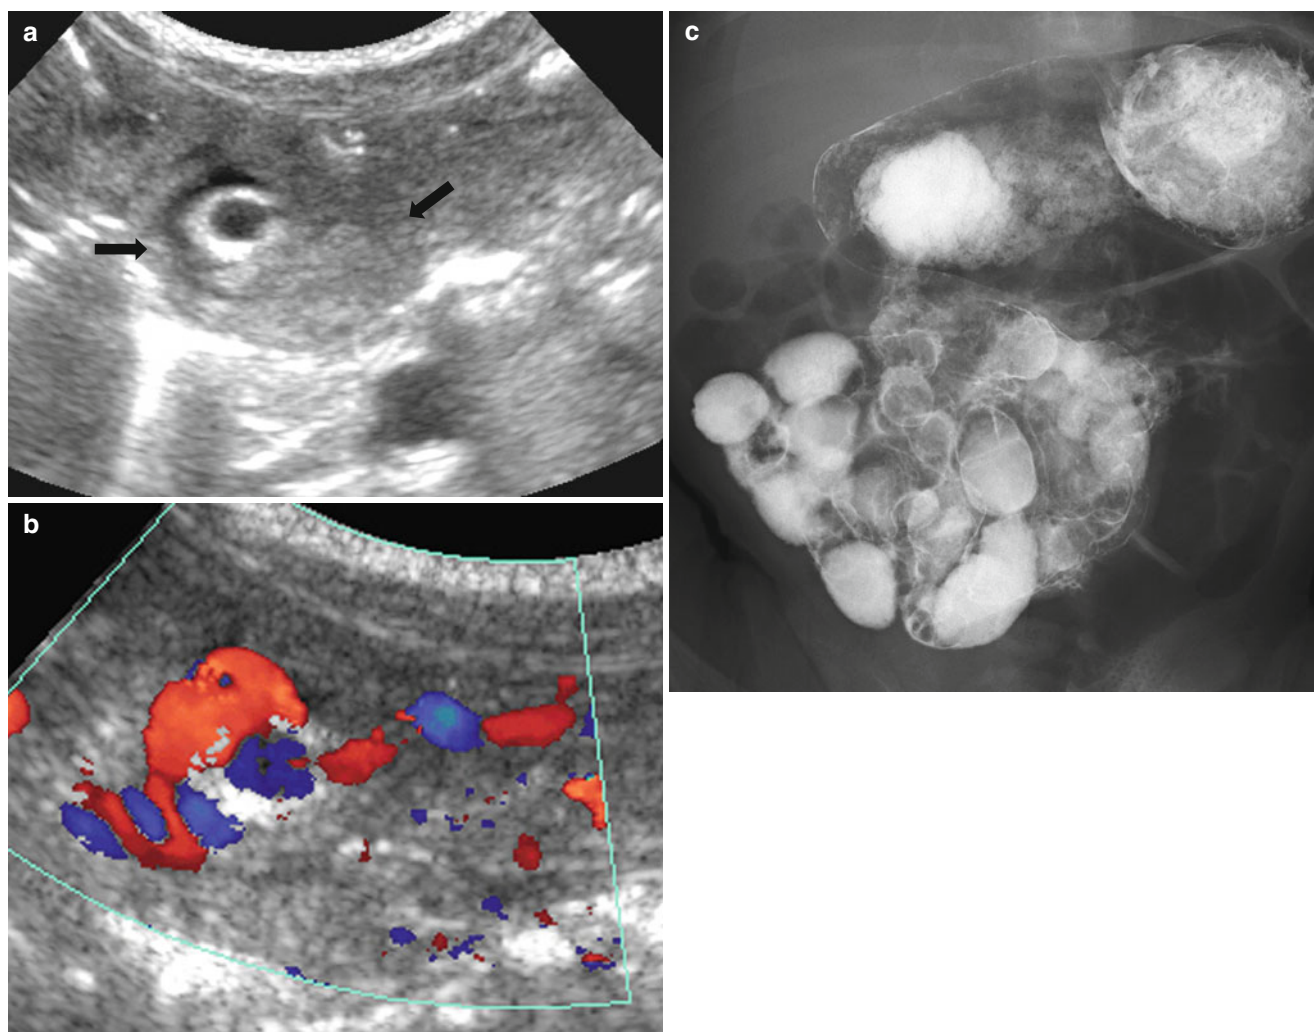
Midgut malrotation and volvulus in a 5-day-old neonate with bloody vomiting and abdominal distension. (a) Transverse US demonstrates a poorly defined, heterogeneously hypoechoic mass lesion with an inner anechoic lesion (arrows). (b) Color Doppler study confirms a clockwise whirlpool sign. Note an inner round anechoic
